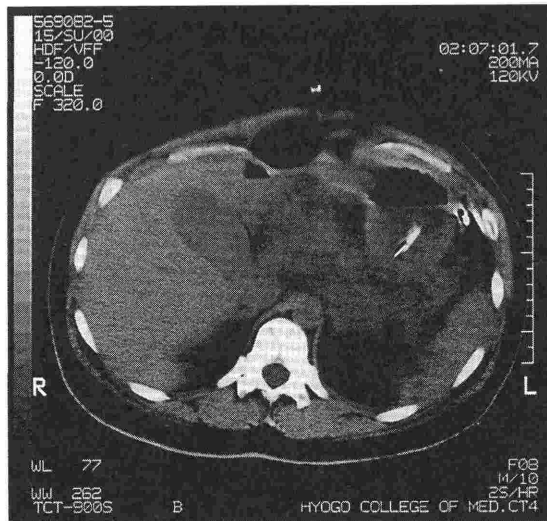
Abdominal computed tomographic (CT) scanning immediatery after surgery
